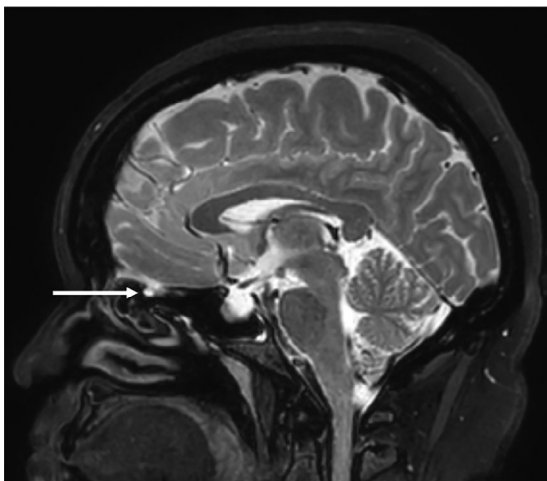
T2-weighted magnetic resonance imaging brain in the sagittal plane demonstrating encephalocele projecting from the right olfactory fossa (arrow).
